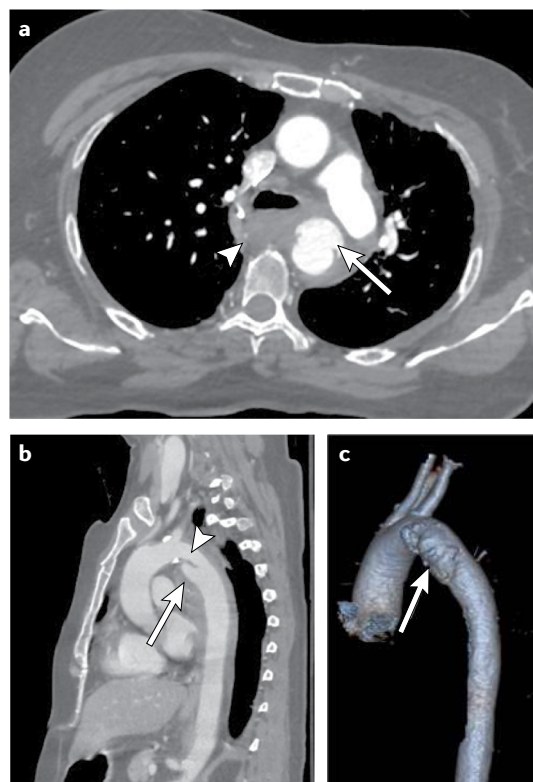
Traumatic aortic pseudoaneurysm. a | Axial contrast-enhanced CT image showing the irregular and enlarged contour of the proximal descending aorta, with evidence of pseudoaneurysm in the superior aspect of the vessel (arrow) associated with mediastinal haematoma (arrowhead). b | Sagittal contrast-enhanced CT reconstruction confirming the pseudoaneurysm (arrow) with intimal flap (arrowhead) at the isthmus level. c | 3D surface contrast-enhanced CT reconstruction clearly depicting the traumatic pseudoaneurysm involving the aortic isthmus (arrow). Images courtesy of L. Romano (A. Cardarelli Hospital, Naples, Italy).
